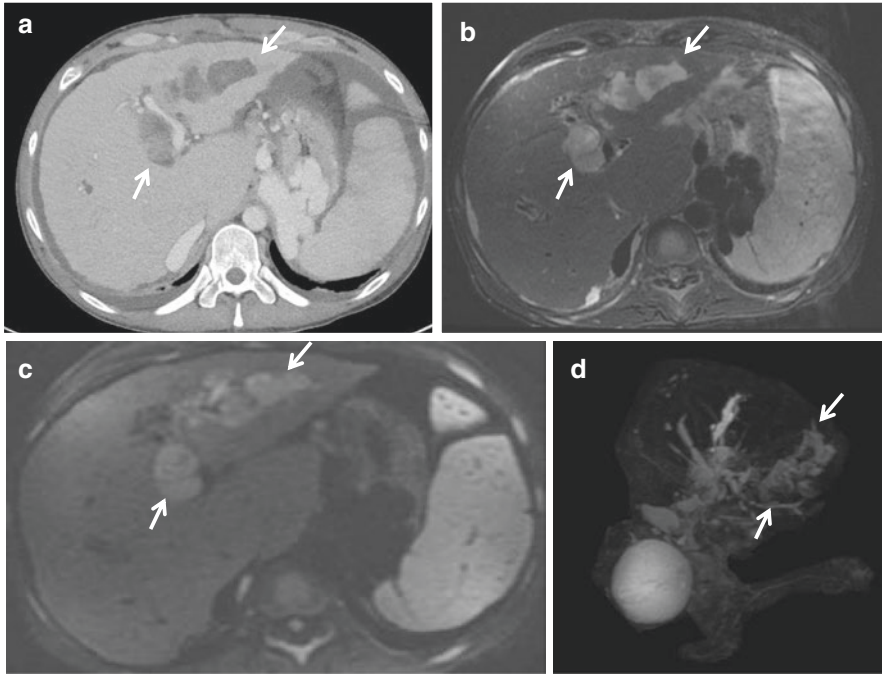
Intraductal intrahepatic cholangiocarcinoma (iCCA) in a patient with ulcerative colitis and primary sclerosing cholangitis evaluated with CT and MRI/MRCP. The ill-defined mass in the left hepatic lobe is (a) hypodense with minimal enhancement on portal venous phase CT (white arrows) and shows (b) T2-weighted hyperintensity (white arrow) and (c) DWI-weighted hyperintensity (white arrow) on MRI. (d) Coronal MIP MRCP shows marked intraductal/periductal irregularity of the intrahepatic bile ducts in the left hepatic lobe (white arrows). CT computed tomography, MRI magnetic resonance imaging, MRCP magnetic resonance cholangiopancreatography, DWI diffusion-weighted imaging, MIP maximum intensity projection
